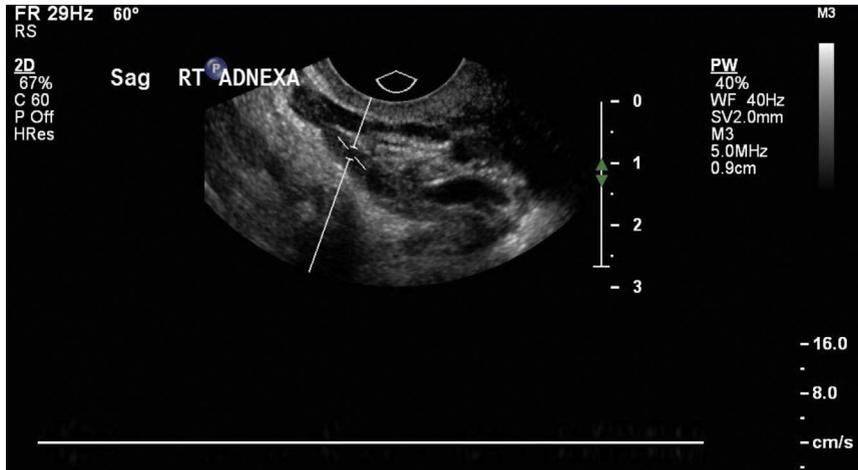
Pulse-waved Doppler study. Right ovarian vein with absent pulse-waved Doppler flow, which is suggestive of thrombosis.
